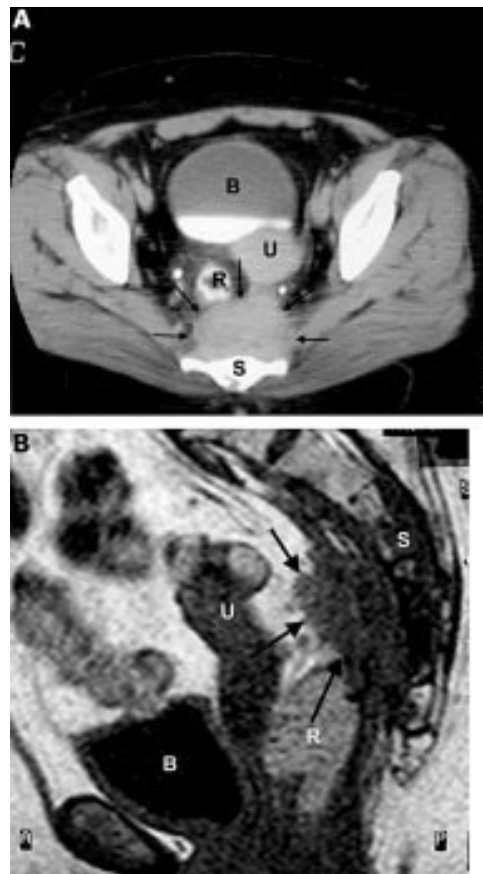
(A) Axial computed tomography scan cut through the pelvis depicting the presacral tumour (arrows). Notice the adjacent structures: B, bladder; R, rectosigmoid; U, uterus; S, sacrum. (B) Sagittal T1 weighted magnetic resonance image through the pelvis. Notice the invasive growth of the tumour (arrows) in the sacrum (S), as demonstrated by the low signal intensity of the involved vertebral bodies. Notice adjacent structures: B, bladder; U, uterus; R, rectum.
